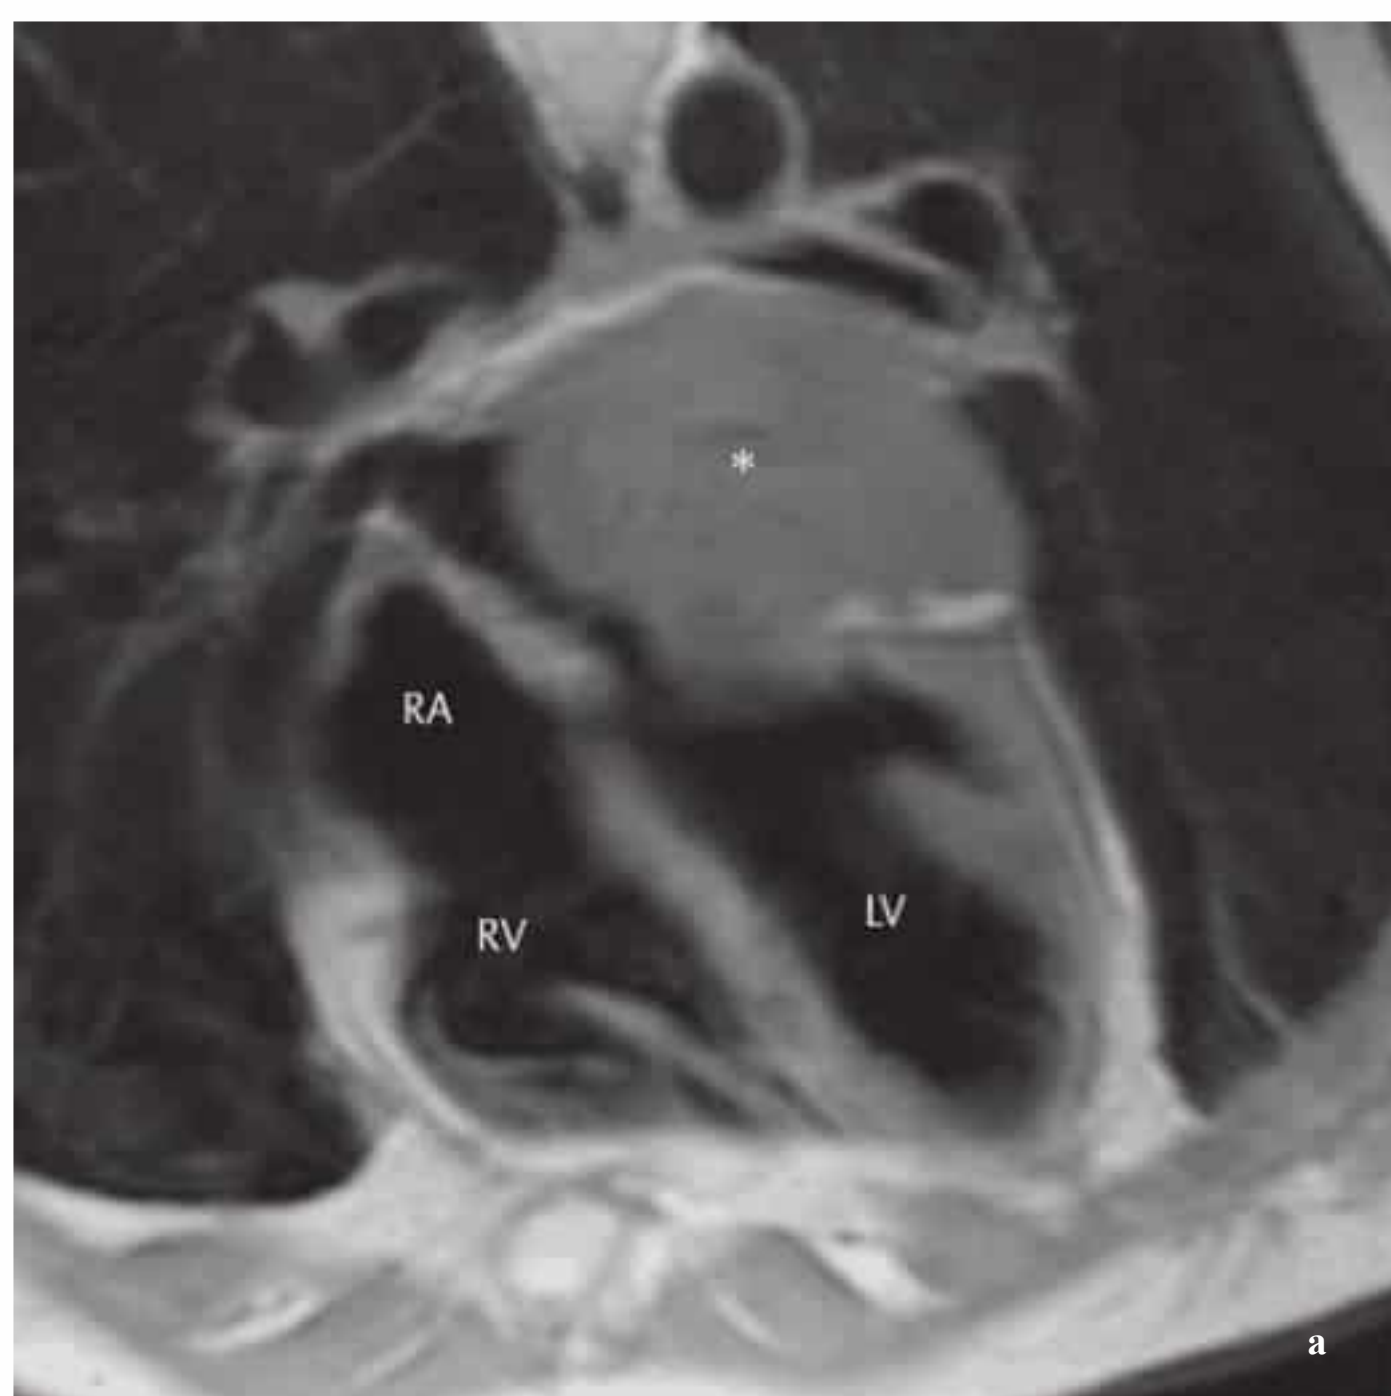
a, b Undifferentiated sarcoma (asterisk) occupies almost the entire left atrium and extends beyond the atrial cavity. It has a homogeneous appearance in the precontrast T1-weighted image (a) and shows marked inhomogeneous contrast enhancement (a) (arrows).
